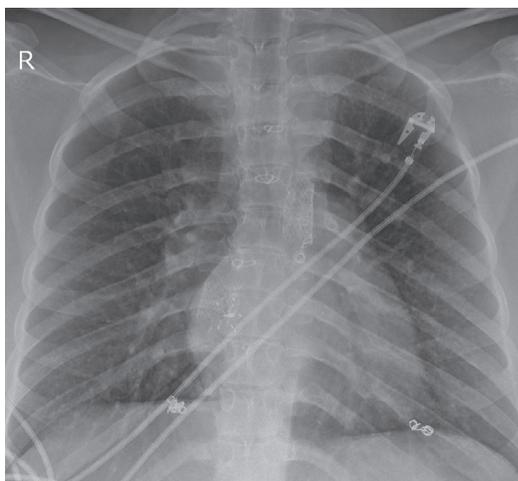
PA chest radiograph in a 22-year-old patient with hypoplastic left heart and a left aortic arch, initially treated with Blalock-Taussig shunt, subsequently replaced by a Glenn procedure and Fontan procedure with creation of an atrial septal defect (ASD). The ASD has been closed percutaneously, and a stent has been placed to revise the Fontan baffle to the pulmonary artery.
